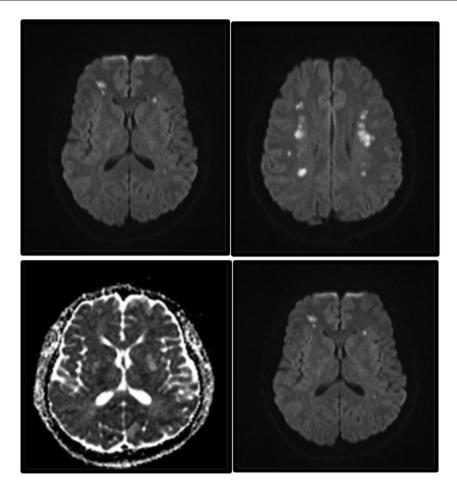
MRI study. Axial DWI/ADC sequence at the level of the basal ganglia and centrum semiovale, showing multiple small acute ischaemic lesions in both hemispheres.
